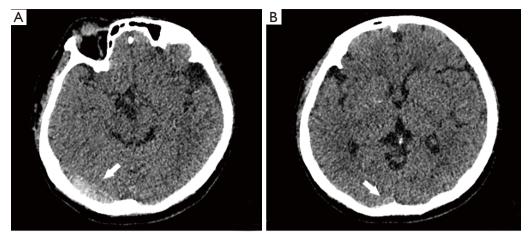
CT before treatment demonstrated high-density areas in the right transverse sinus (A, arrow) and superior sagittal sinus (B, arrow).
